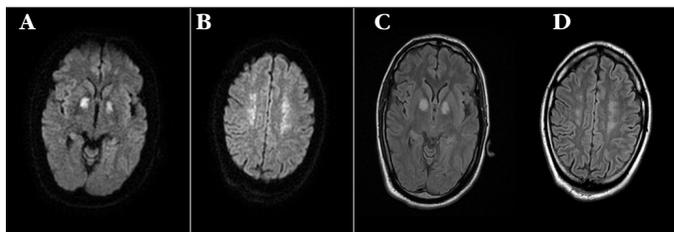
A 31-year-old male, carbon monoxide intoxication; signal increase in bilateral globus pallidus in diffusion-weighted images (A, B) and FLAIR (C, D) magnetic resonance imaging
